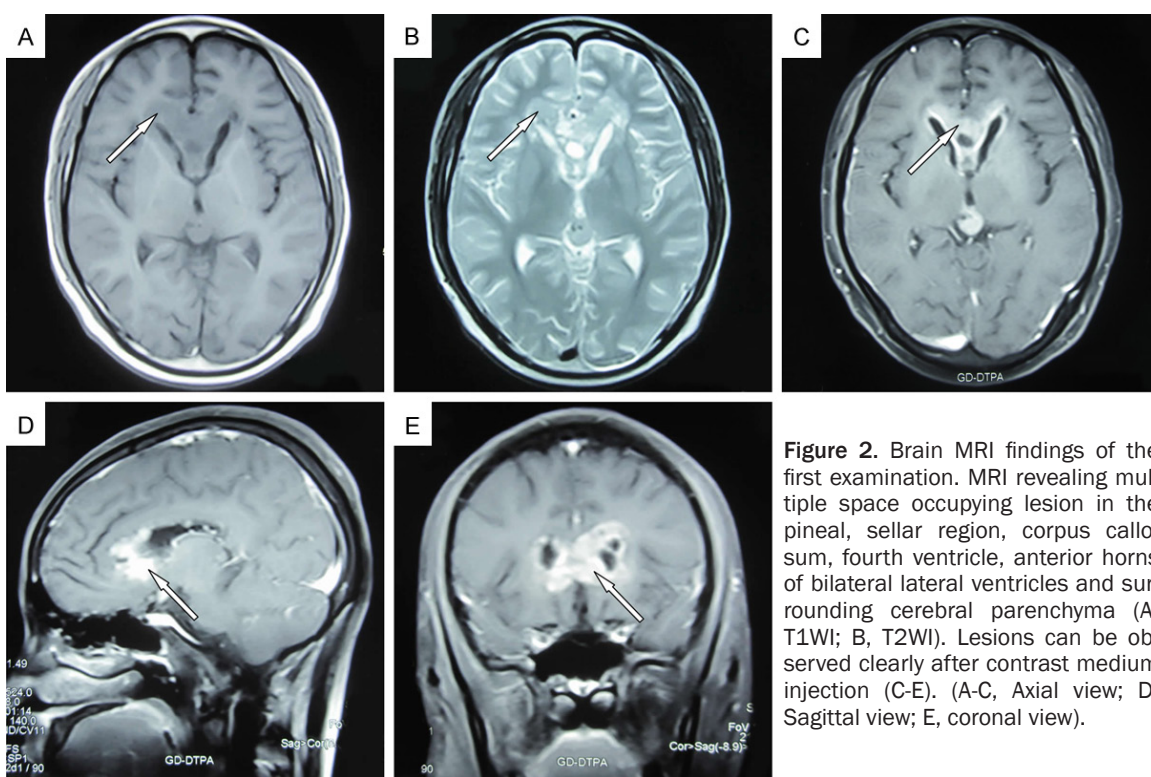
Brain MRI findings of the first examination. MRI revealing multiple space occupying lesion in the pineal, sellar region, corpus callosum, fourth ventricle, anterior horns of bilateral lateral ventricles and surrounding cerebral parenchyma (A, T1WI; B, T2WI). Lesions can be observed clearly after contrast medium injection (C-E). (A-C, Axial view; D, Sagittal view; E, coronal view).
